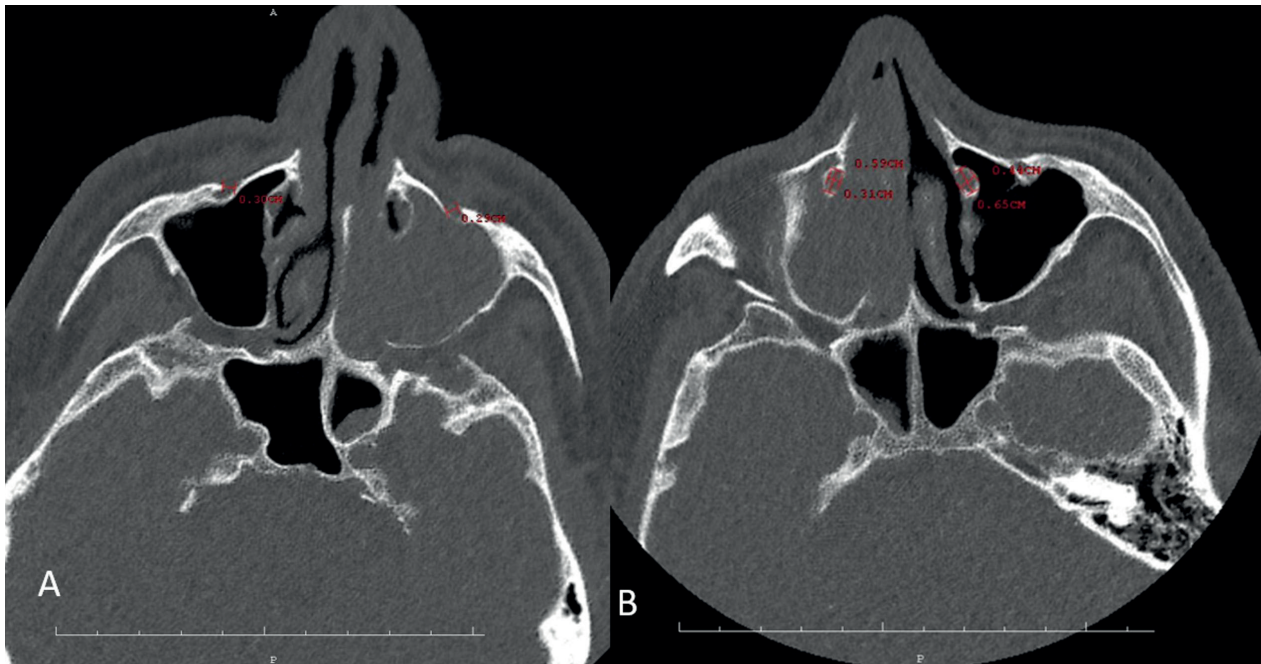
In axial parasagittal sinus CT examination, the measurement method of the infraorbital canal at the level of the inferior orbital rim (A) and the nasolacrimal canal at the level of the middle turbinate (B) are shown.
